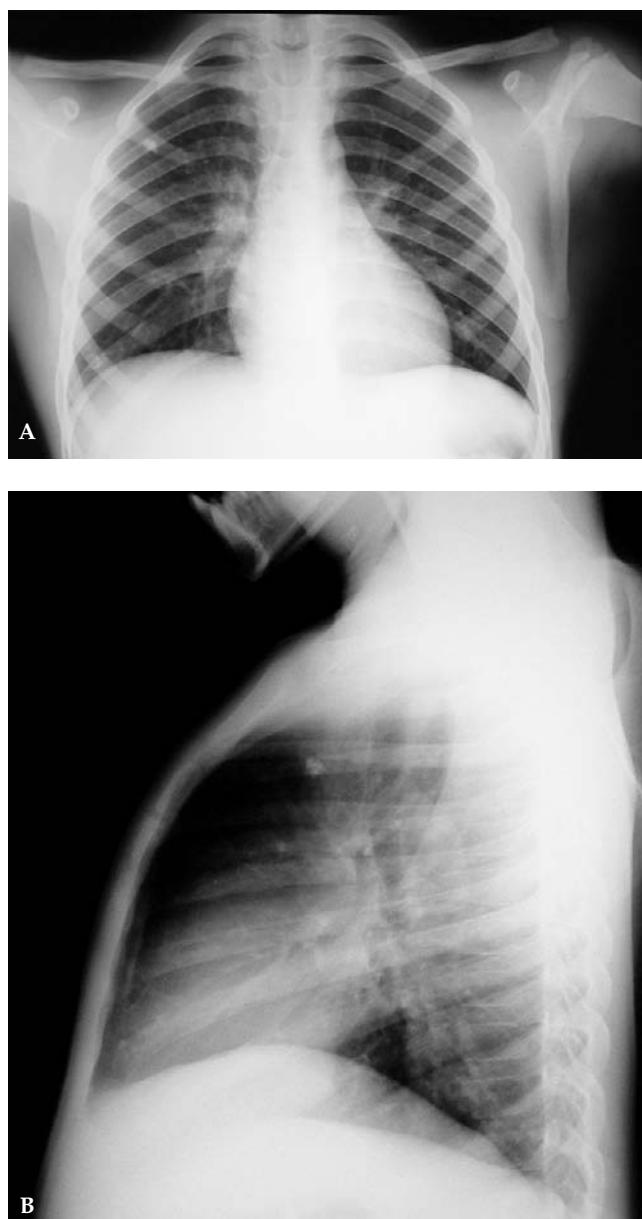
Anteroposterior (A) and lateral (B) chest radiographs in May 2003, showing an isolated calcified granuloma in the right upper lobe, but no other abnormality.
